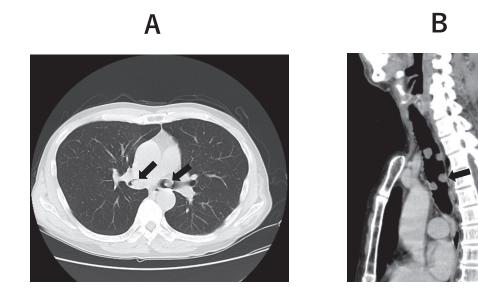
Chest CT in case 1A: Sagittal image. Multiple lesions protruding into the trachea (black arrow).B: Coronal image. Protruding lesion in the main bronchus.
